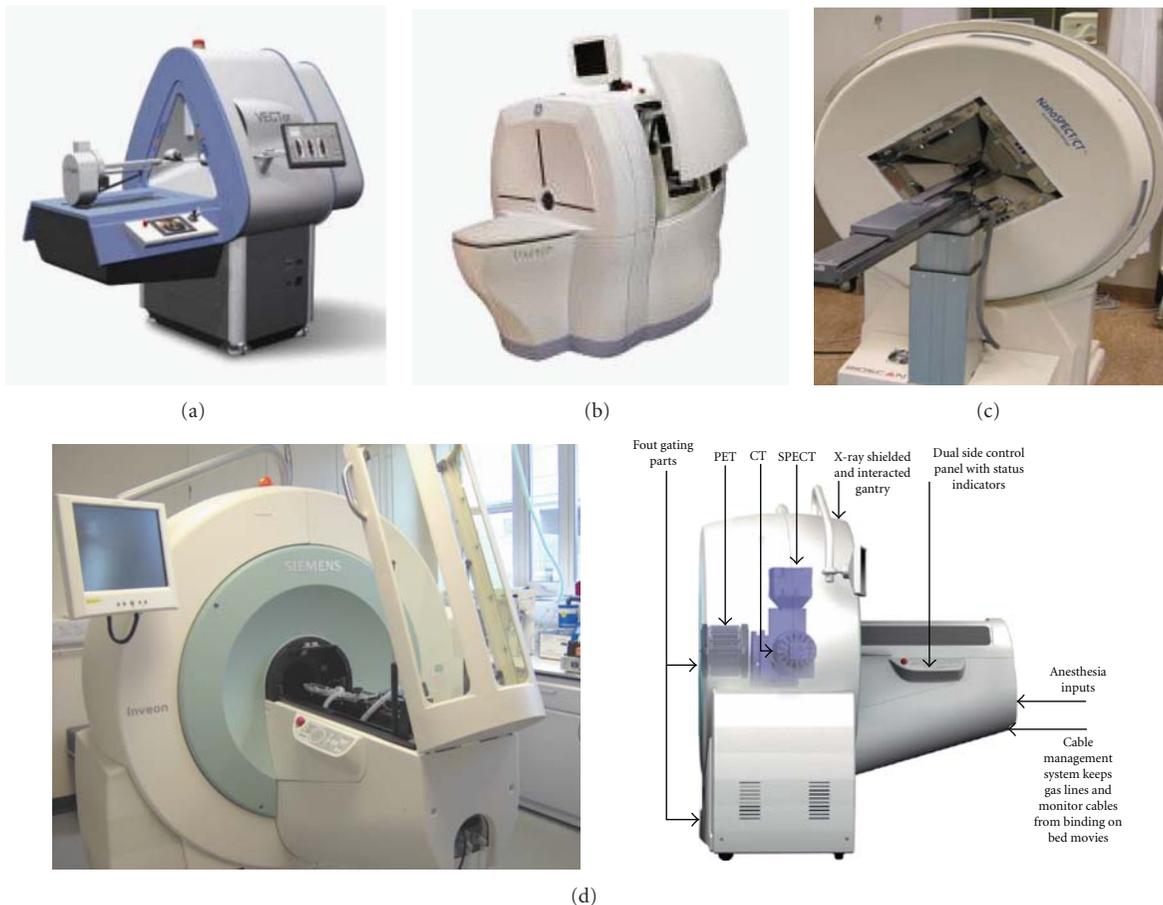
Some commercial preclinical SPECT systems. (a) A preclinical hybrid PET/SPECT device, the VECTor (Image courtesy of MI Labs), (b) Triumph Trimodality scanner (courtesy of Gamma Medica), (c) NanoSPECT (courtesy of BioScan, Inc), and (d) Inveon system (courtesy of Siemens Medical Solution) with internal components demonstrated (courtesy of Siemens Medical Solution).
